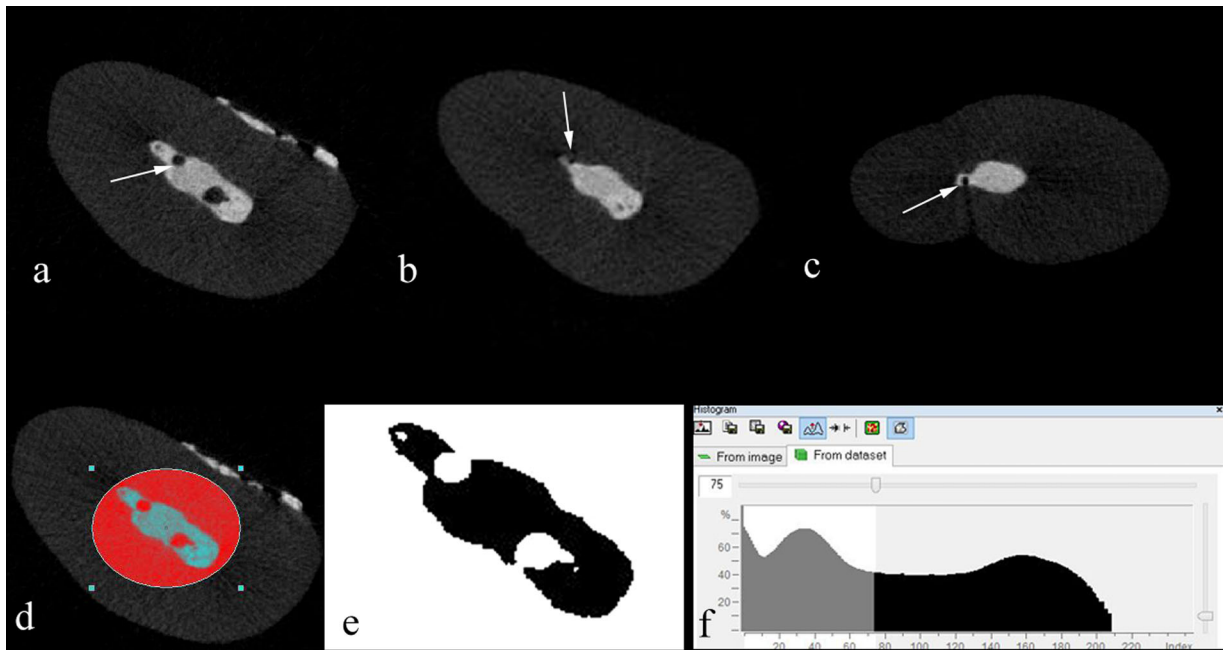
Micro CT images showing (a) internal void, (b) external void, and (c) combined void, (d) ROI selection on images, (e) void detection inside ROI, (f) binarization of the image by the gray-level histogram.
